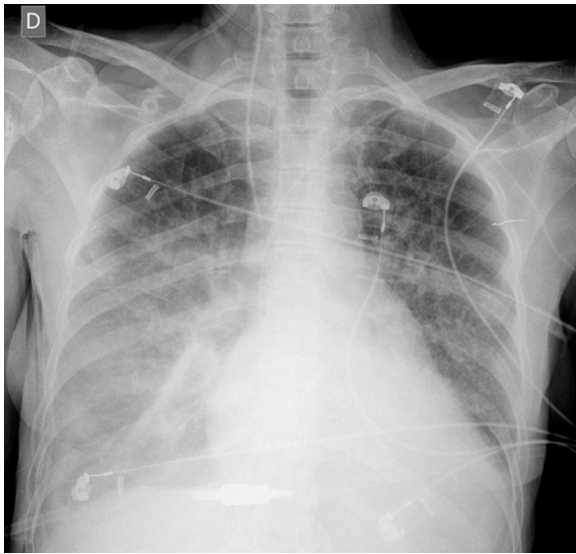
Bilateral pulmonary edema and right-sided pleural effusion on the chest radiograph.
